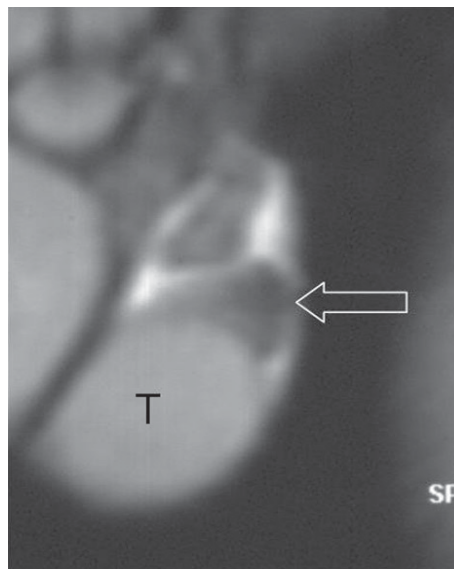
Normal anatomy. Sagittal T2-weighted MR image of normal testicle and epididymis. The testicle (T) shows a homogeneous structure. The head of the epididymis (arrow) appears hypointense
